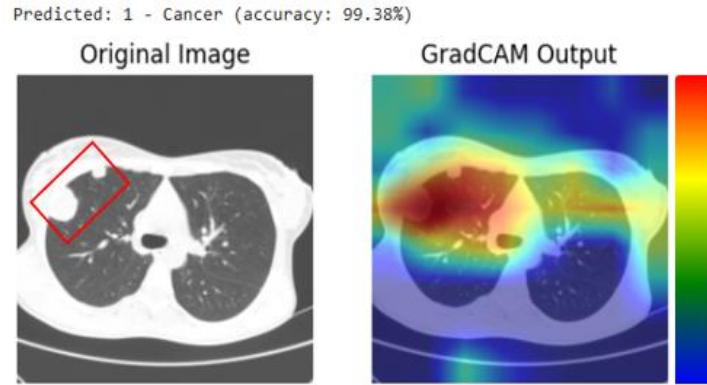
GradCAM result of CT image with a model of Xception
